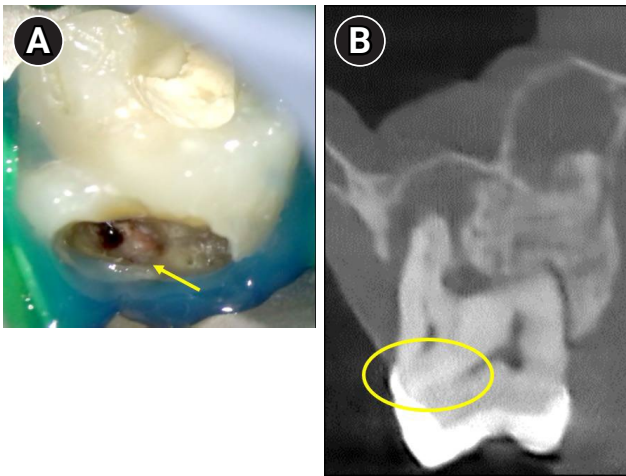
Difficulty in identifying the palatal canal due to the presence of a localized cervical mineralized diaphragm (CMD) near the palatal region. (A) Clinical view showing a mineralized barrier (yellow arrow) obstructing access to the palatal canal. (B) Cone-beam computed tomography image revealing CMD in the palatal area (highlighted with a yellow circle).
